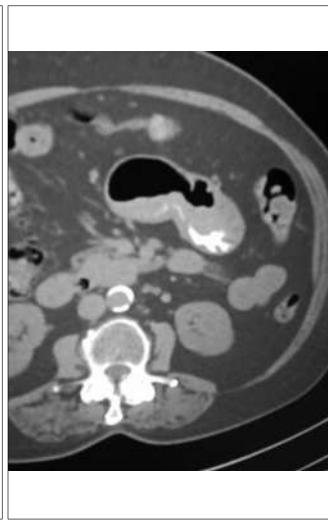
CT scan abdomen showing calcification of the posterior gastric wall.
